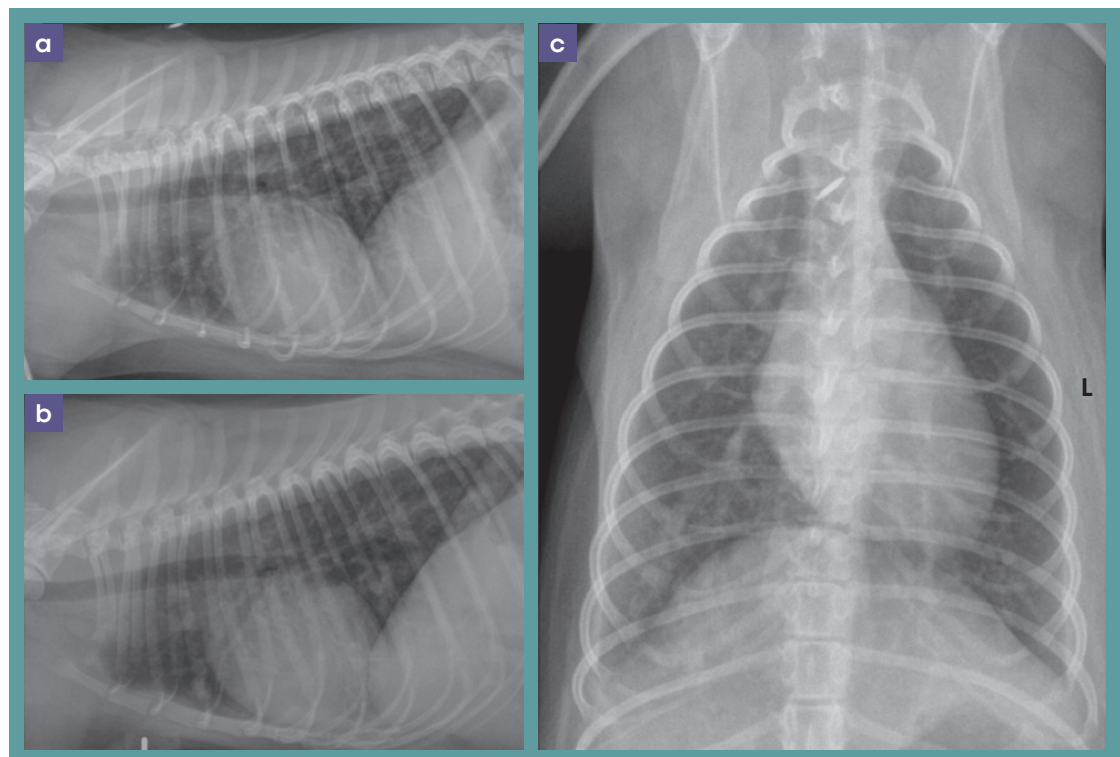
Thoracic radiographs. Right lateral (a), left lateral (b), and dorsoventral (c) projections showing patchy and mainly peripheral areas of increased opacity and a diffuse bronchointerstitial pattern.
